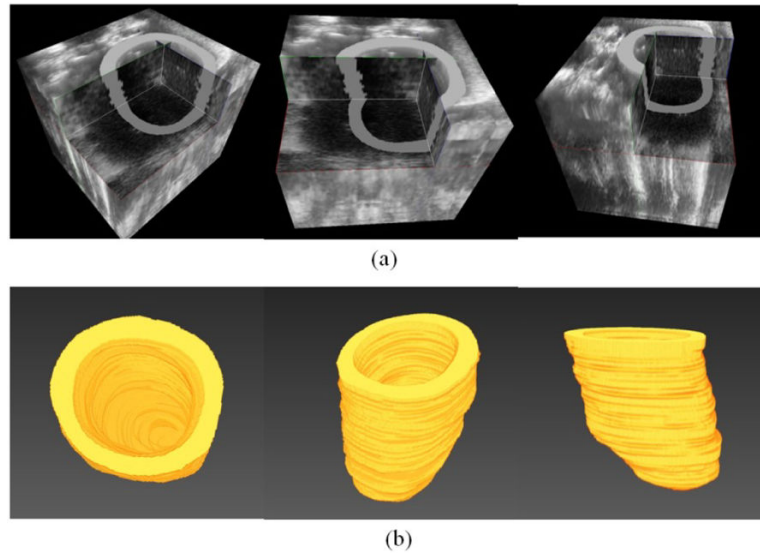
Reconstructed ultrasound volume and the segmented heart geometry. (a) Ultrasound volume in the end of the diastole phase. (b) Segmented and reconstructed 3D geometry of the heart.
